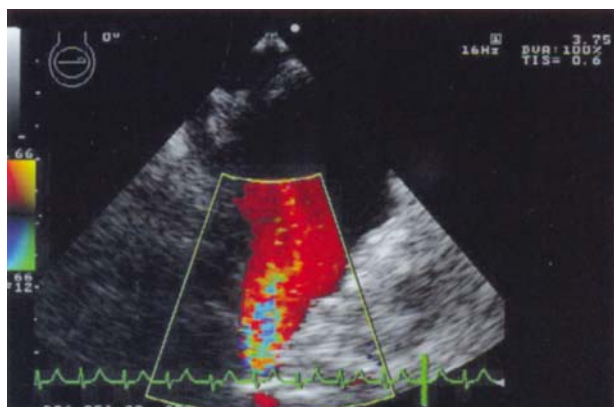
Colour flow Doppler of left atrial appendage after heart transplantation showing effective atrial contraction.
